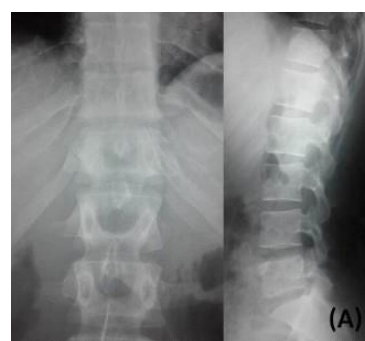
Standard x-ray (Anteroposterior and lateral view) showing a disappearance of normal contours of the right pedicle of T12.
